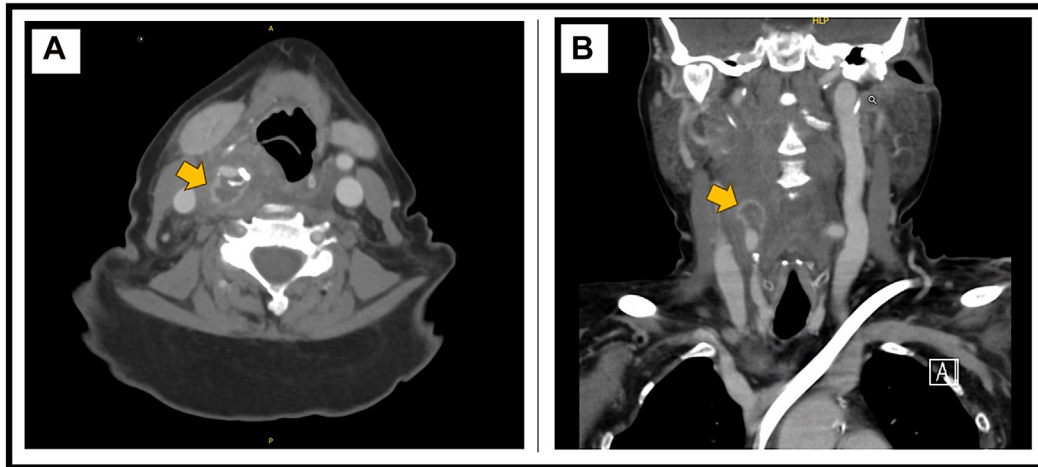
Axial (A) and coronal (B) views of preoperative computed tomography angiography (CTA) showing a hypodense mass with contrast-enhanced rim surrounding a calcified right carotid artery bifurcation, indicating a carotid sheath abscess.
